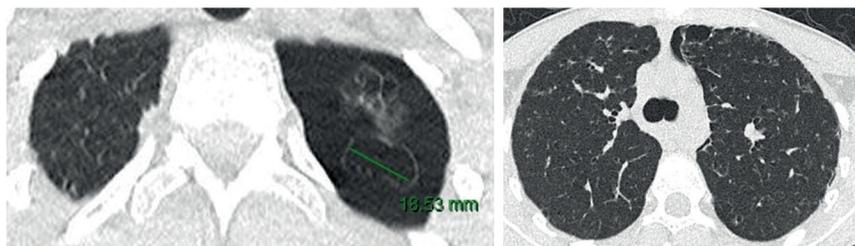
HRCT showing pseudocysts (on the left image) and reticular pattern with bronchiectasis and nodules (on the right image).
